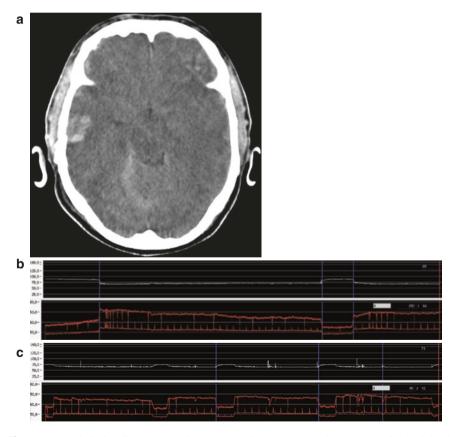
(a) Admission CT scan showing temporal right contrecoup hemorrhage, right subdural hematoma, subarachnoidal hematoma, and basal skull fracture. (b) Autonomic monitoring day 1: fluctuations of heart rate, blood pressure according to intracranial pressure fluctuations. Upper trace (*white*) heart rate, lower trace (*red*) systolic and diastolic blood pressure. (c) Autonomic monitoring day 3: increased frequency of fluctuations. Upper trace (*white*) heart rate, lower trace (*red*) systolic and diastolic blood pressure
